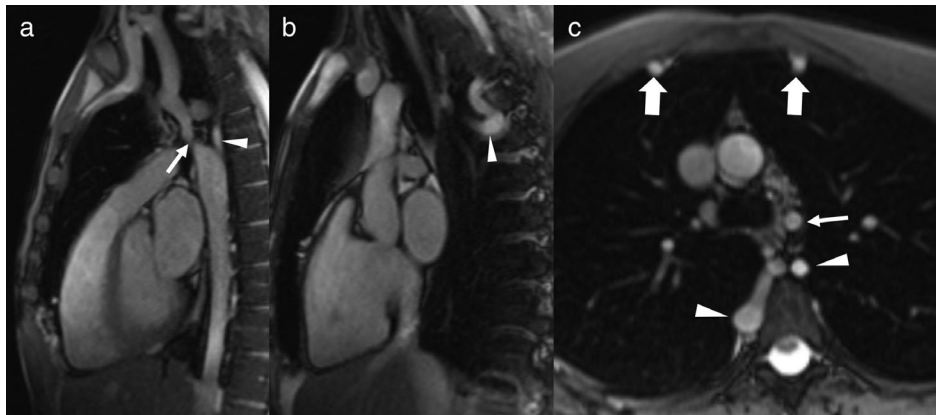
bSSFP MRI of aortic coarctation in a 20-year-old man. Sequential oblique sagittal single-shot bSSFP MR images (a,b) demonstrate severe narrowing at the level of the aortic isthmus (thin arrow), consistent with aortic coarctation. There are multiple enlarged intercostal arteries (arrowheads), providing collateral flow to the descending aorta. Transaxial single-shot bSSFP MR image (c) also shows enlargement of the internal mammary arteries (thick arrows). The patient subsequently underwent surgical repair with an interposition graft.
